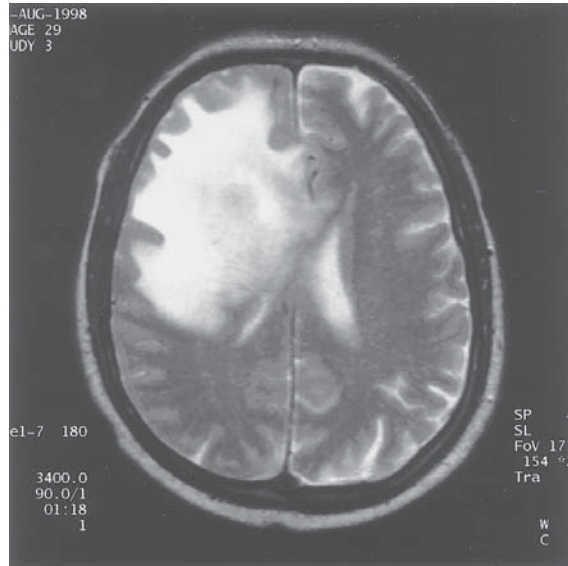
MRI scan of the brain (T2 images) demonstrating edema from a large right frontal metastasis.
